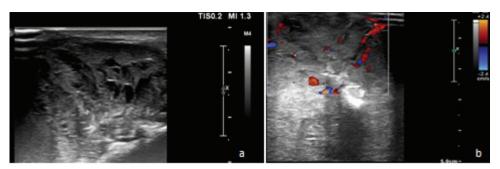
Ultrasound examination. (a) Grayscale image shows slightly heterogenous mass with few necrotic areas. (b) The lesion shows increased vascularity within the mass.
